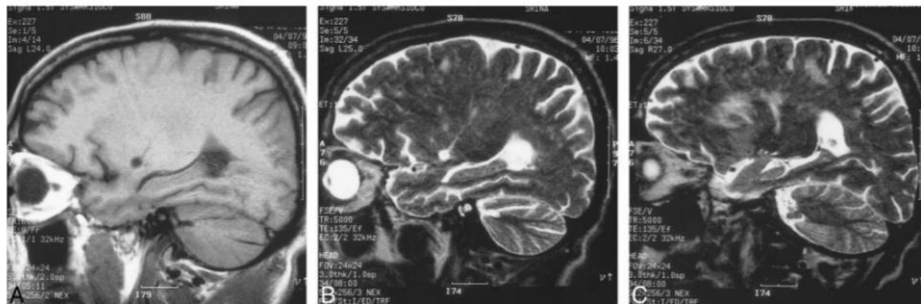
A and B, 45-year-old man. Sagittal T1-weighted (600/9/2) (A) and T2-weighted (5000/135/3) (B) MR images show a long track with a cavity in the left putamen (low signal in A and high signal in B).
